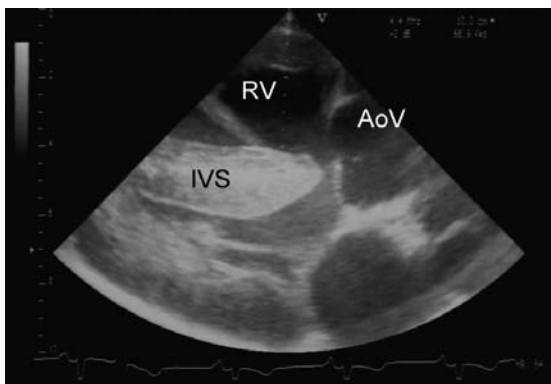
Right parasternal long-axis view at end systole. Dextropositioning of the aorta and ventricular septal defect. AoV = aortic valve; RV = right ventricle; IVS = interventricular septum.
